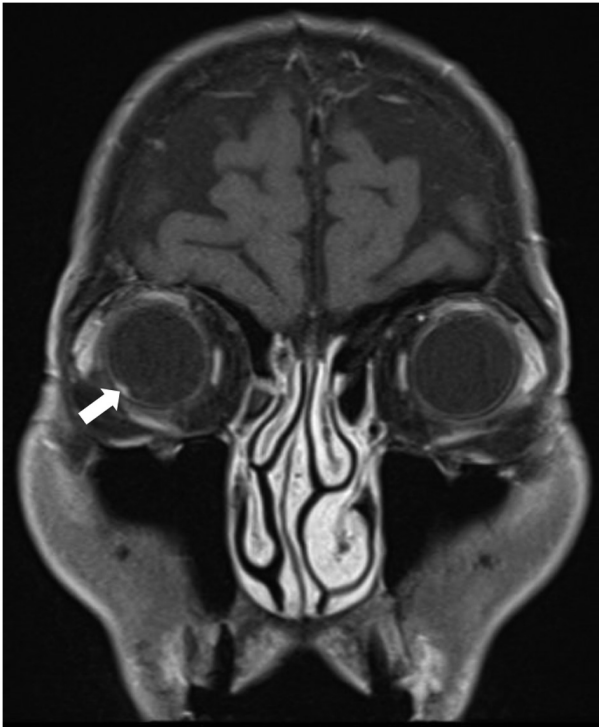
Image acquired from magnetic resonance imaging performed before stereotactic radiotherapy revealing an enhanced choroidal mass (arrow) measuring 4 mm in diameter.
